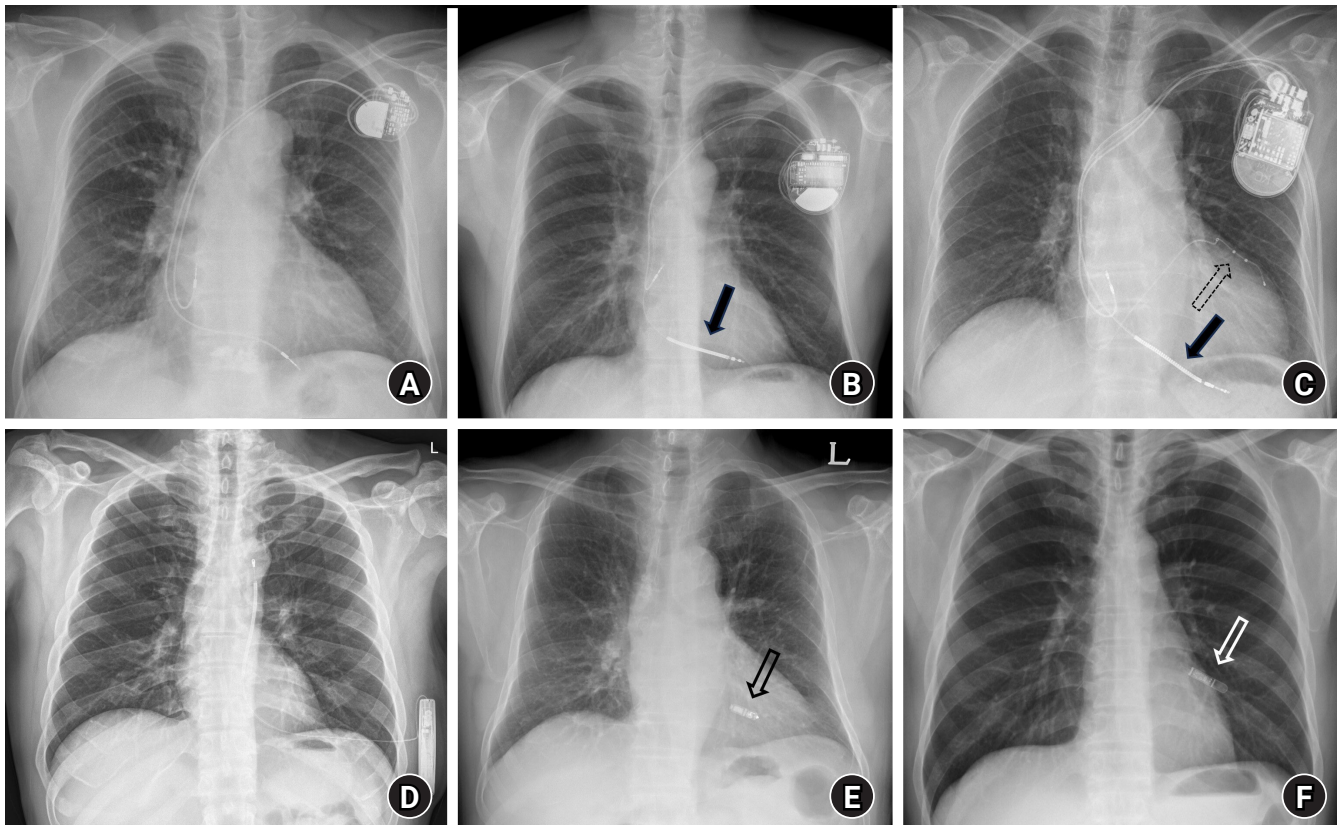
Typical examples of chest X-ray images in patients with cardiac implantable electronic devices. (A) Permanent pacemaker. (B) Implantable cardioverter defibrillator (ICD). (C) Cardiac resynchronization therapy-defibrillator. (D) Subcutaneous ICD. (E) Leadless pacemaker. (F) Implantable loop recorder (ILR). Black filled arrows show the shock coils of the ICD lead with a radio-opaque section. The black dotted arrow denotes the left ventricular lead for cardiac resynchronization. The black empty arrow shows the leadless pacemaker within the myocardium of the right ventricle. The white empty arrow shows the ILR within the left chest wall.
